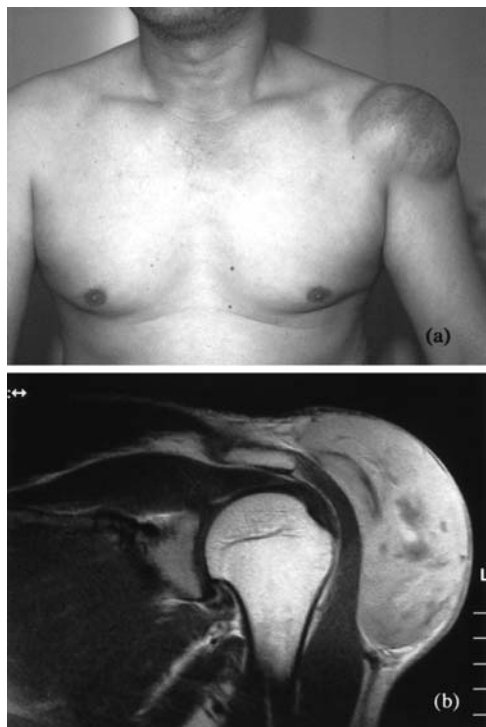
a In the first local recurrence, the patient's shoulder mass measured about 4 cm. b Coronal magnetic resonance imaging (MRI) scans of the left shoulder. On T₁-weighted images with Gd enhancement, MRI scans revealed a homogeneous high-intensity mass over the deltoid muscle
